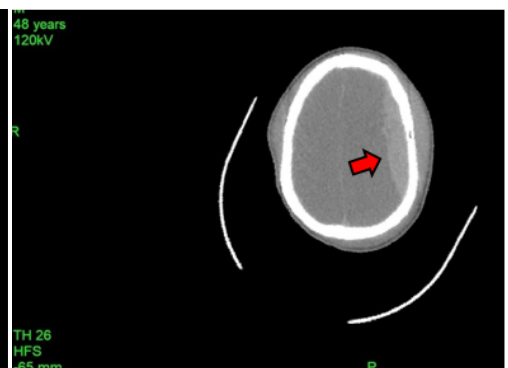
CT brain showing EDH with fracture of parietal bone and scalp hematoma
